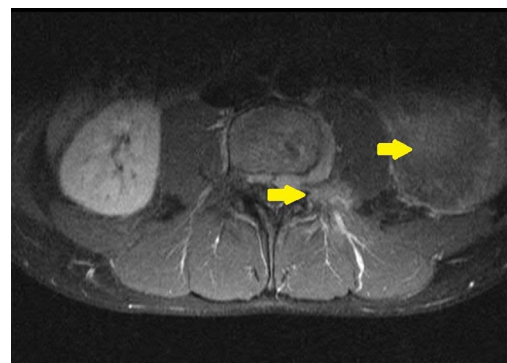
Transverse MRI demonstrating L4 vertebral metastasis. Metastatic deposit within the L4 vertebral body and pedicle extending posteriorly into the left epidural space, abnormal left kidney.
